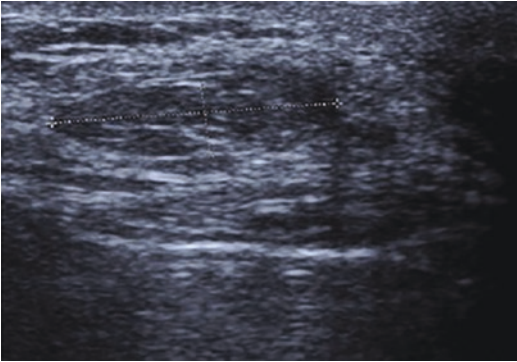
Sonographic appearance of a subcutaneous lipoma
